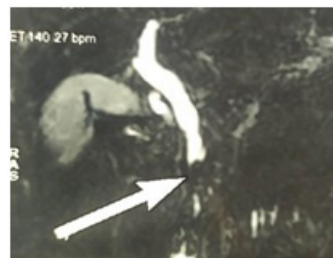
Frontal section of a biliary MRI showing irregular stenosis of the lower bile duct
